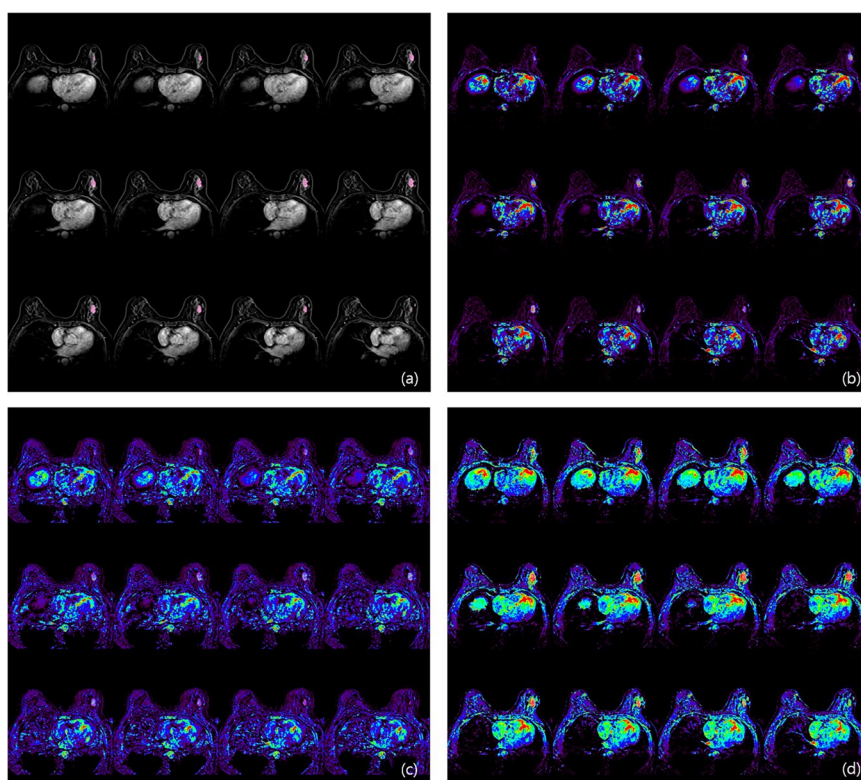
Evaluation of perfusion parameter. (a) On Fat-saturated T1-weighted images, tumor segmentation was performed with semi-automatic tool (magic wand tool). After applying tumor segmentation on Ktrans map (b), Kep map (c) and Ve map (d), perfusion parameters from each map were calculated.
